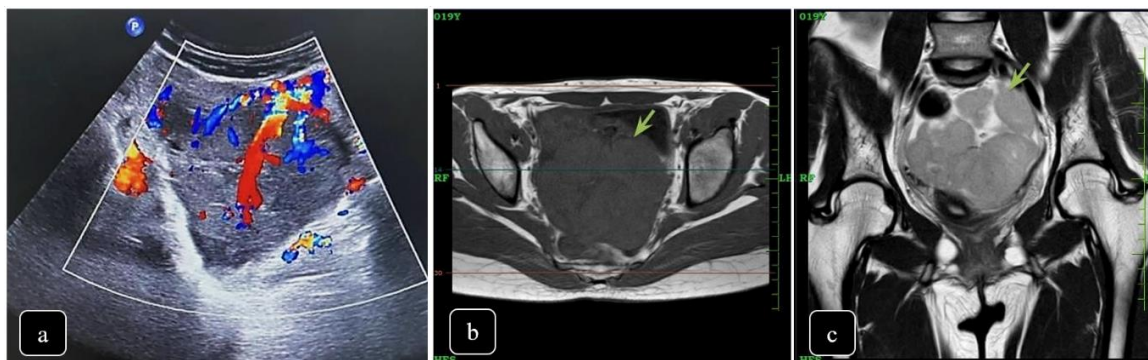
(a) Transvaginal ultrasound shows a fairly defined lobulated solid heterogeneous lesion in the left adnexa with significant internal vascularity. MRI Axial and coronal section shows a large, well defined, lobulated, thin walled Pelvico-abdominal solid lesion (green arrow) is seen replacing the left ovary. T1 (b) Focal multi-lobulated heterogenous hypointense and T2 (c) heterogenous hyperintense solid lesion arising from left ovary.
